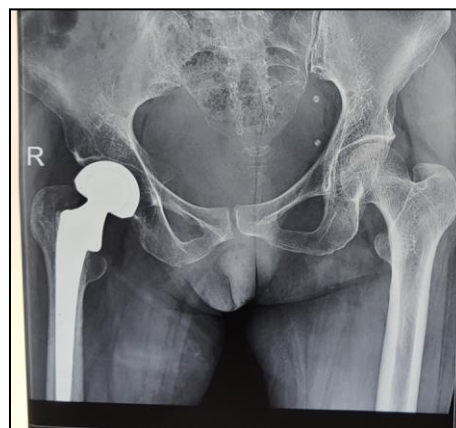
Follow up X-ray at 6 months
